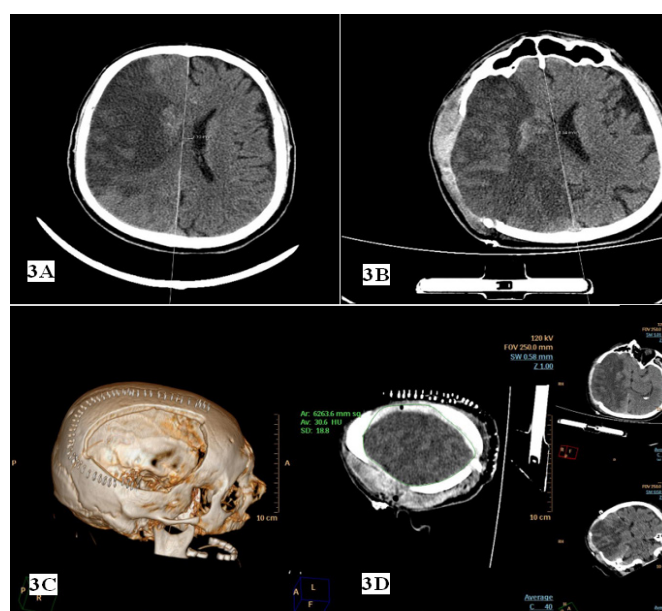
Photographs show the preoperative (3A) and postoperative (3B, 3C) cranial CT images of a patient with stroke. Photographs also show the measurement technique of the craniectomy area in sagittal, coronal, and axial CT images of this patient (4D)
